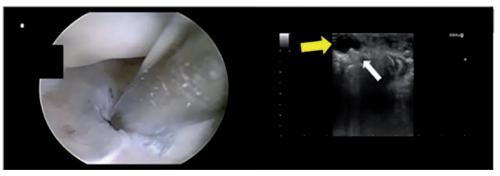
Arthroscopic and sonographic view
